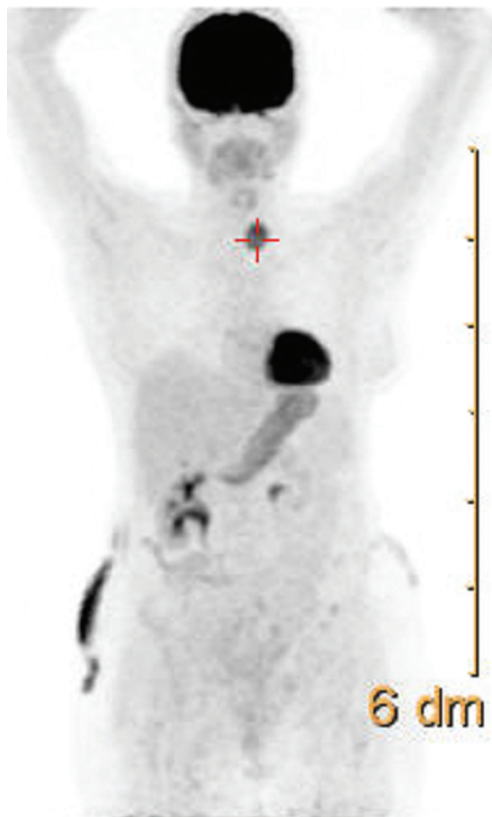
Physiologic uptake of the 18F-FDG-PET true-out the body in the heart, right kidney after the surgery and hypermetabolic increased uptake of the 18F-FDG in the left anterior part of the neck base
